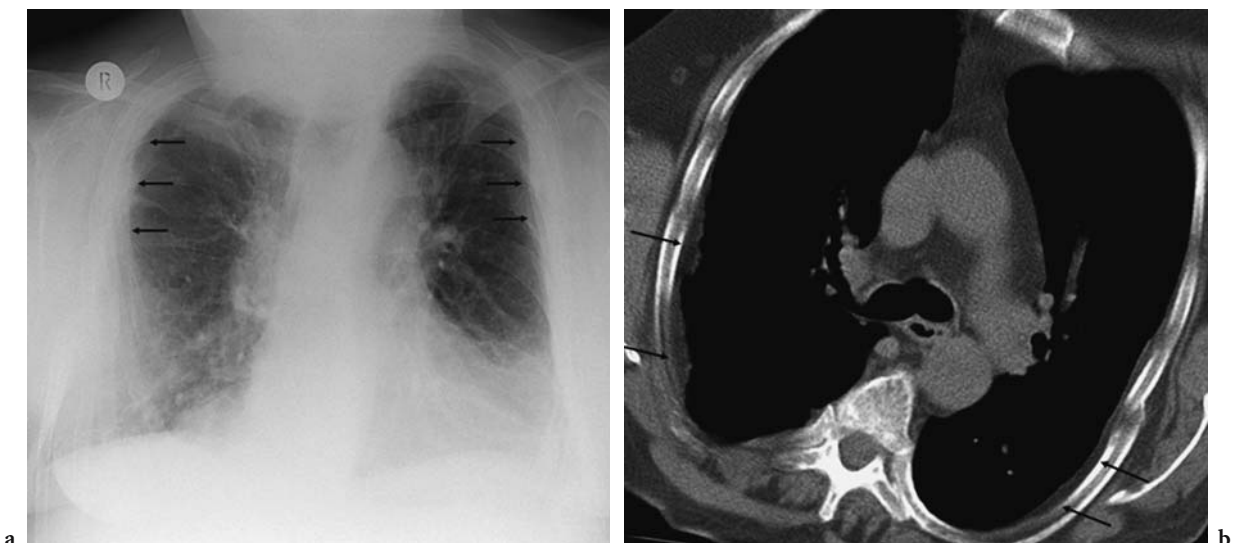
Bilateral pleural thickening (*arrows*) documented on a chest radiograph (a) which on computed tomography (b) was found to represent extrapleural fat (*arrows*)
